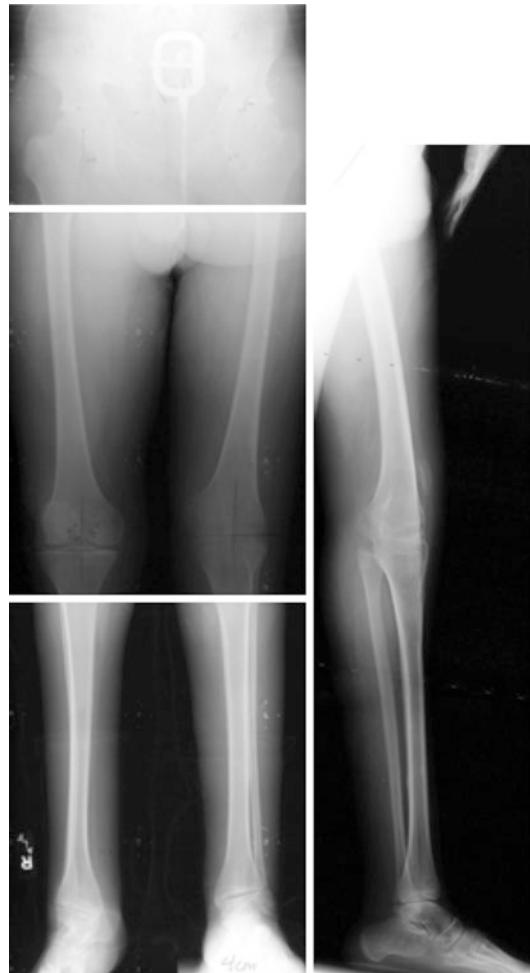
Case 1:* Standing anteroposterior (AP) (left) and lateral (right) radiographs of 26-year-old male with history of arthrogryposis and knee fusion. Note that he also has equinovarus deformity of the right foot. The knee fusion is in about 5° of flexion
